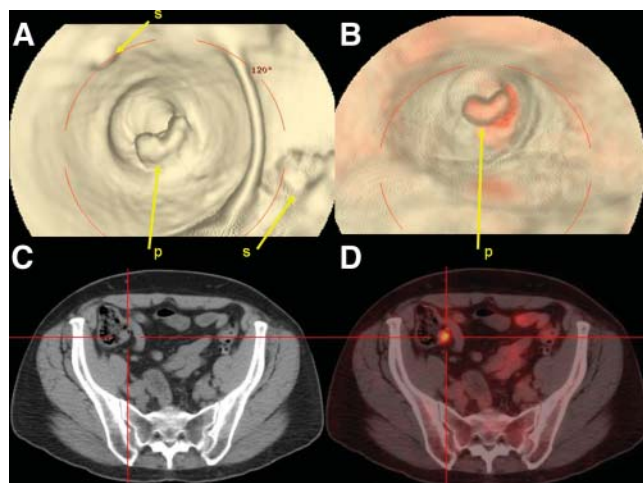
CT virtual colonoscopy compared with PET/CT virtual colonoscopy for detection of a potentially malignant lesion. (A) CT-based virtual colonoscopy showing several areas of stool that are difficult to distinguish from potential malignant polyp. (B) PET/CT virtual colonoscopy showing intense ^{18}F -FDG uptake that highlights suspected polyp relative to surrounding stool and greatly aids in differentiation of lesion from stool. (C and D) Retrospective review of standard 2D PET/CT tomographic slices reveals abnormal focus in colon that was missed on original interpretation (C) and would not have been detected without 3D fusion rendering (D). p = polyp; s = stool.
